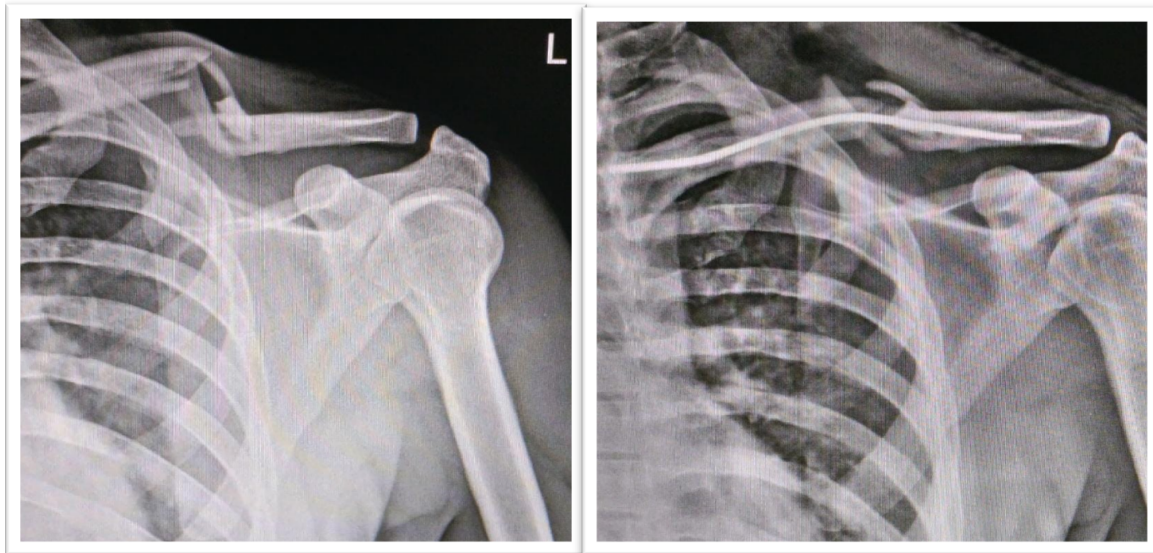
X-Rays showing Displaced fracture of shaft of left clavicle Before (Left) and after intramedullary Nailing (Right)
